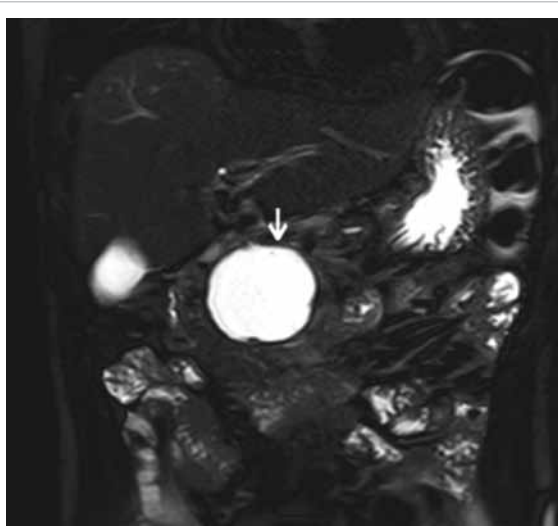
Coronal T2-weighted magnetic resonance image showing a cystic lesion at the pancreatic head (arrow)
